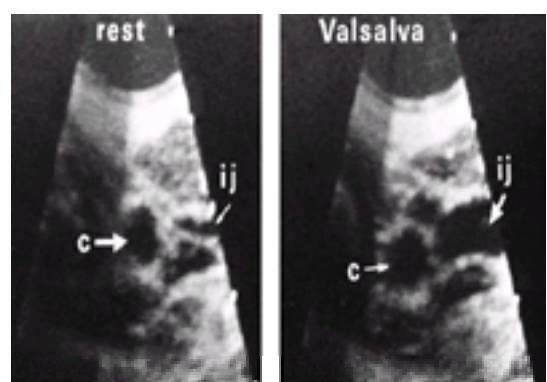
Two-dimensional echocardiographic image of the carotid artery (c) and the internal jugular vein (ij) at rest (left) and during a Valsalva maneuver (right), showing the marked enlargement in jugular venous caliber with increased distending pressure.
